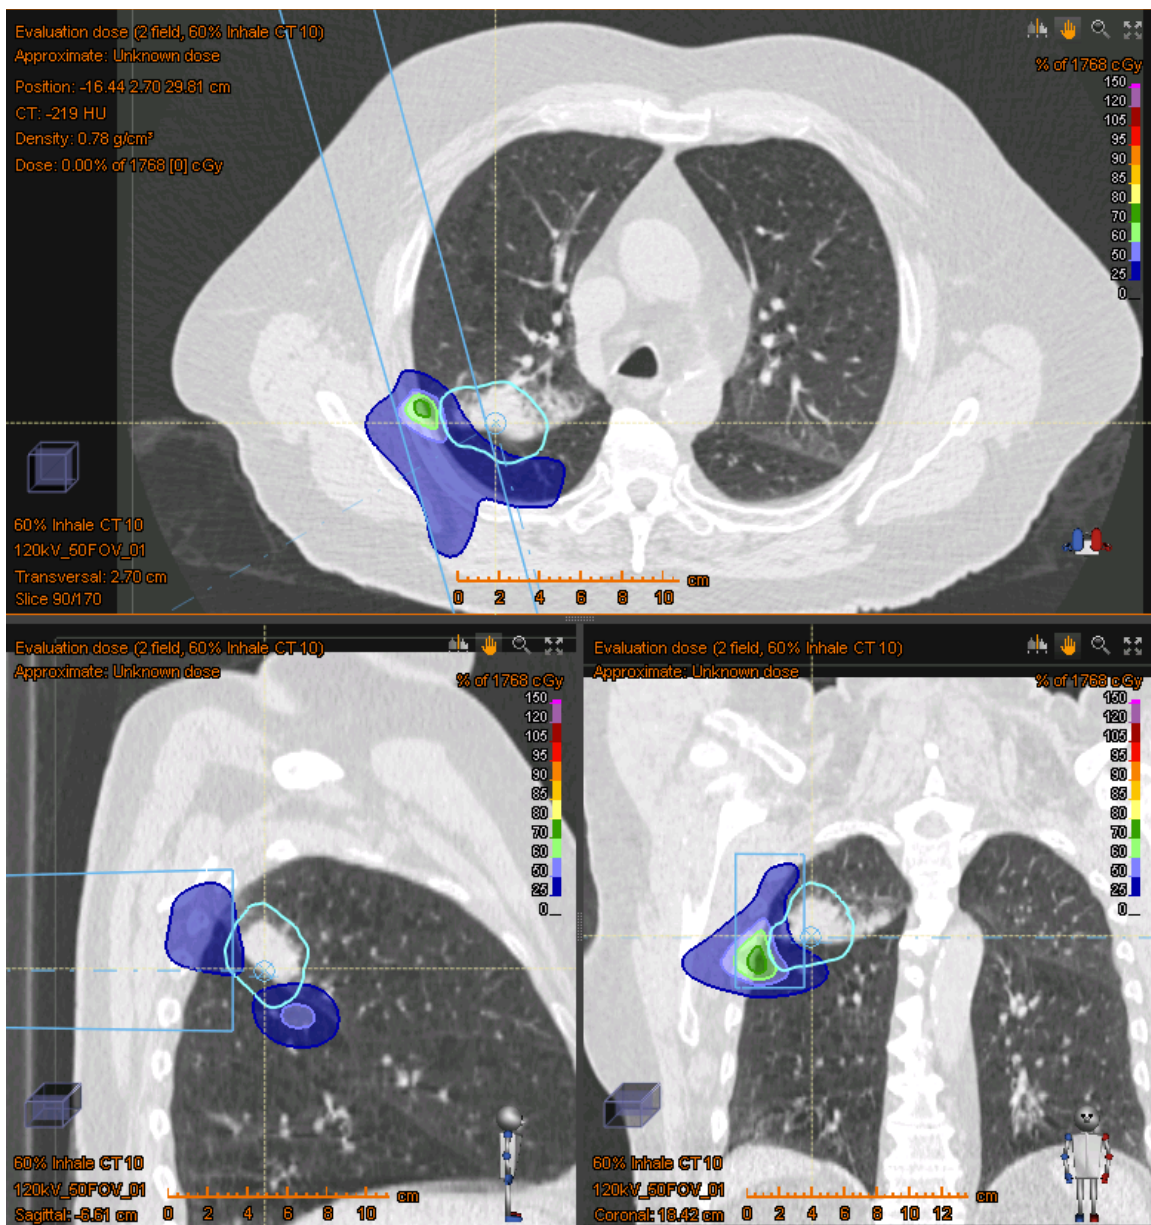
Field 1&2 – Dose delivered to 60% inhale CT phase
